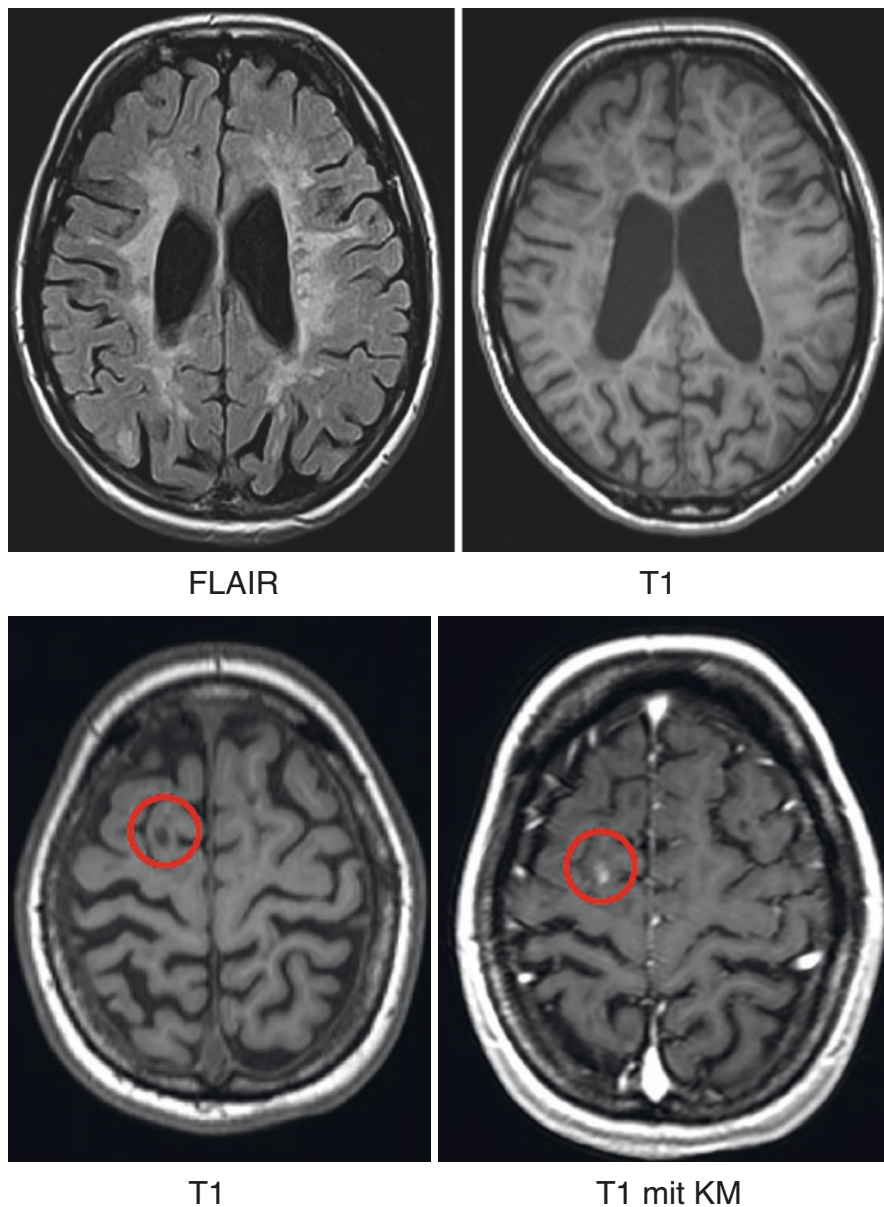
The upper panel shows extensive, confluent, hyperintense and primarily periventricular localized white matter lesions after several years of MS (upper left, T2-FLAIR), some of these lesions are also visible on native T1-weighted images (upper right) by “dark” (hypointense) lesions (“black holes”) representing focal tissue damage. Note: age-related strong expansion of inner and moderate expansion of the outer ventricles representing cerebral atrophy. The lower panel shows native and contrast-enhanced T1-weighted images (“mit KM”), presenting an active lesion (so-called “wet black hole” due to formation of edema). This represents active disease
